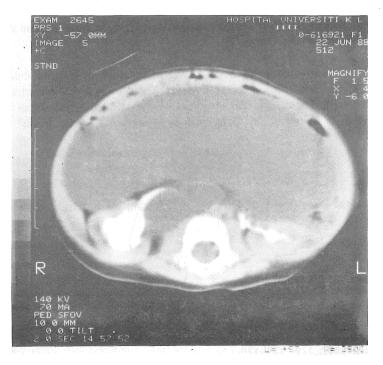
Computed tomography of the abdomen showing a large cystic abdominal mass and a hydronephrotic right kidney.
